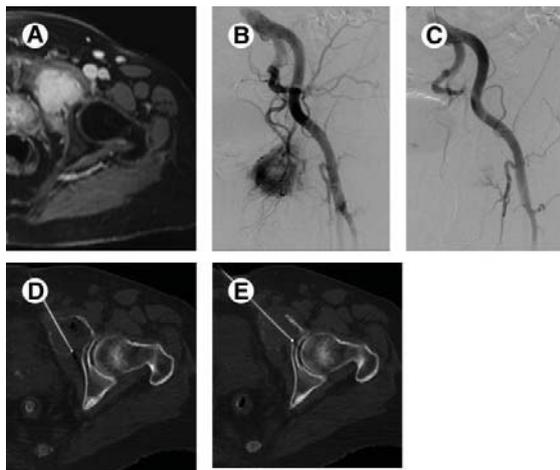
A) MR image shows hypervascular metastases of the left pubic ramus B) Angiogram of the common iliac artery shows hypervascular mass supplied by the obturator branch of the internal iliac artery C) Post TAE angiogram of the common iliac artery showing D) and E) Axial, non-contrast enhanced CT images showing RFA [8]
